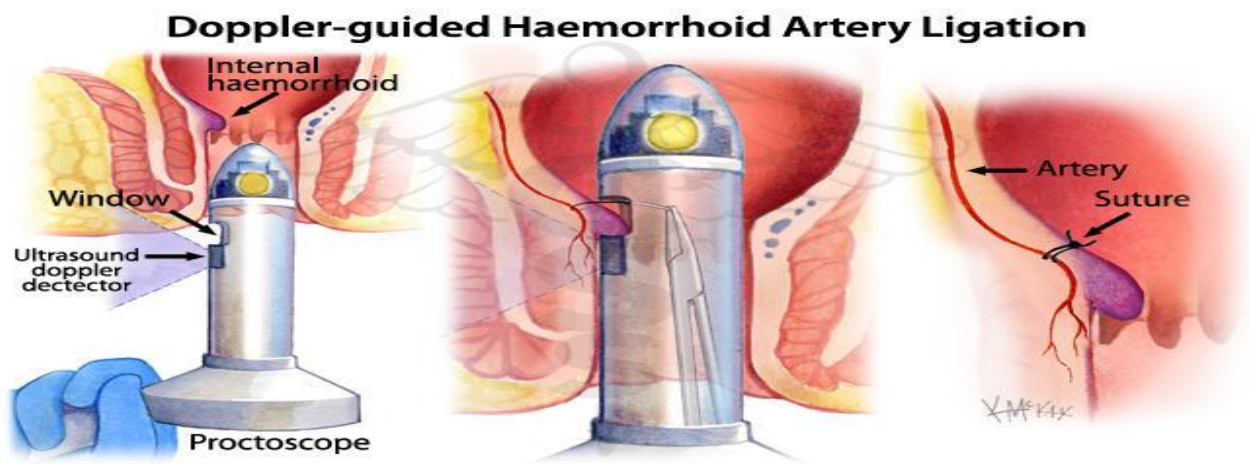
Doppler-Guided Haemorrhoid Artery Ligation (HAL)
